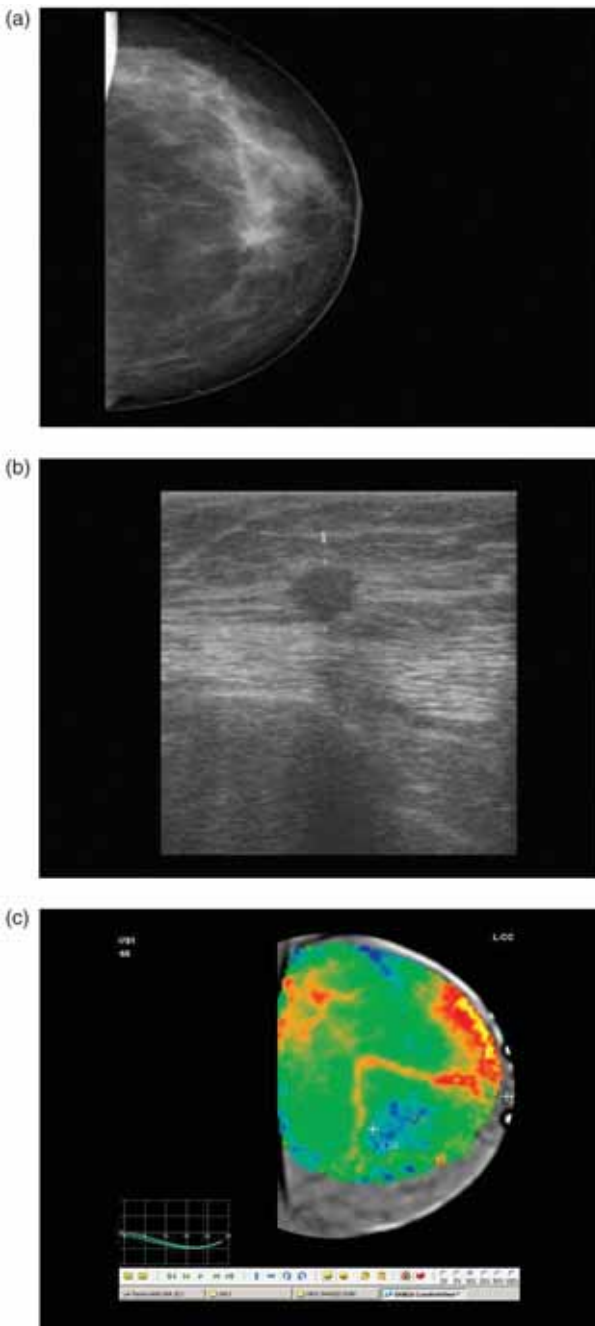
Case 1. (a) Mammographic images in craniocaudal view clearly depict a stellated lesion classified as BIRADS 5, with a high suspicion of malignancy. (b) High-resolution ultrasonography with a 10 mHz probe shows that the mammographic lesion corresponds to a hypoechoic, irregular nodule, BIRADS 5. (c) Dynamic optical imaging shows that the corresponding area of interest is highly hypoxic, with negative down slope dynamic curves, that strongly suggest an underlying malignant lesion.
